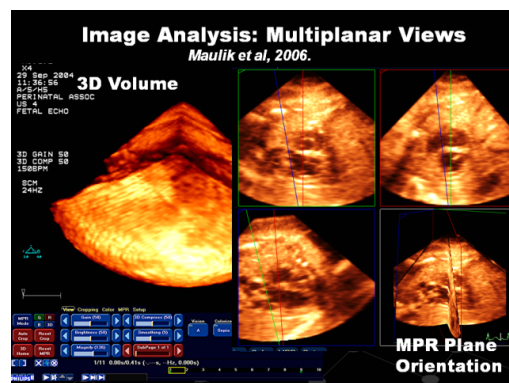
Real time 3D fetal echocardiogram showing cardiac structures following cropping in two orthogonal planes and rotating the image data set.
